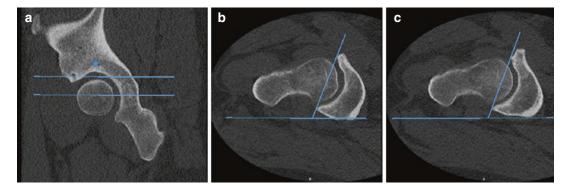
Computed tomography of the right hip. Panel a shows a sagittal view with the 12 o'clock (blue star), 1 o'clock (upper line), and the 3 o'clock (lower line) positions marked. Panel b shows the measured version through
